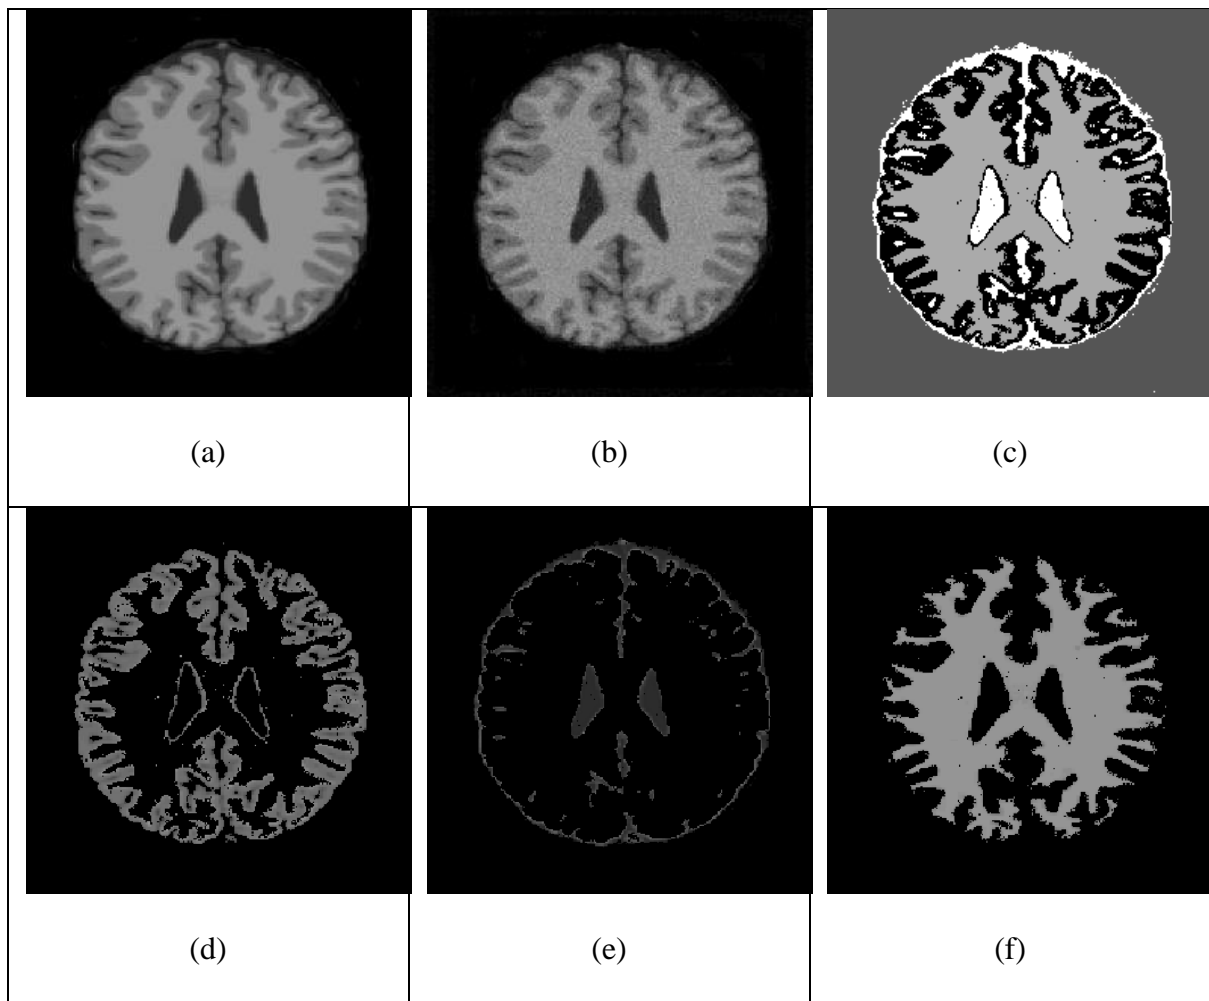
(a) Normal Brain(T1-weighted slice 99), (b) Normal brain (noise 5%), (c) Segmented result using FUZZY GSA, (d) Gray matter, (e) CSF, (f) White matter
